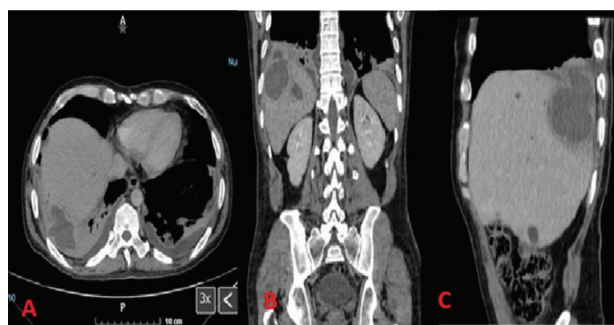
Triphasic computed tomography showing bilateral pleural effusion with atelectasis and consolidation in the right inferior lobe. Hepatic segment VII showing a round, defined, hypodense collection (27-30 UH) of 58 x 74 x 67 mm, with a volume of 149.5 ml. The contrasted phase showing annular enhancement and communication with the pleural cavity. (A) Late axial. (B) Late coronal. (C) Venous sagittal.
